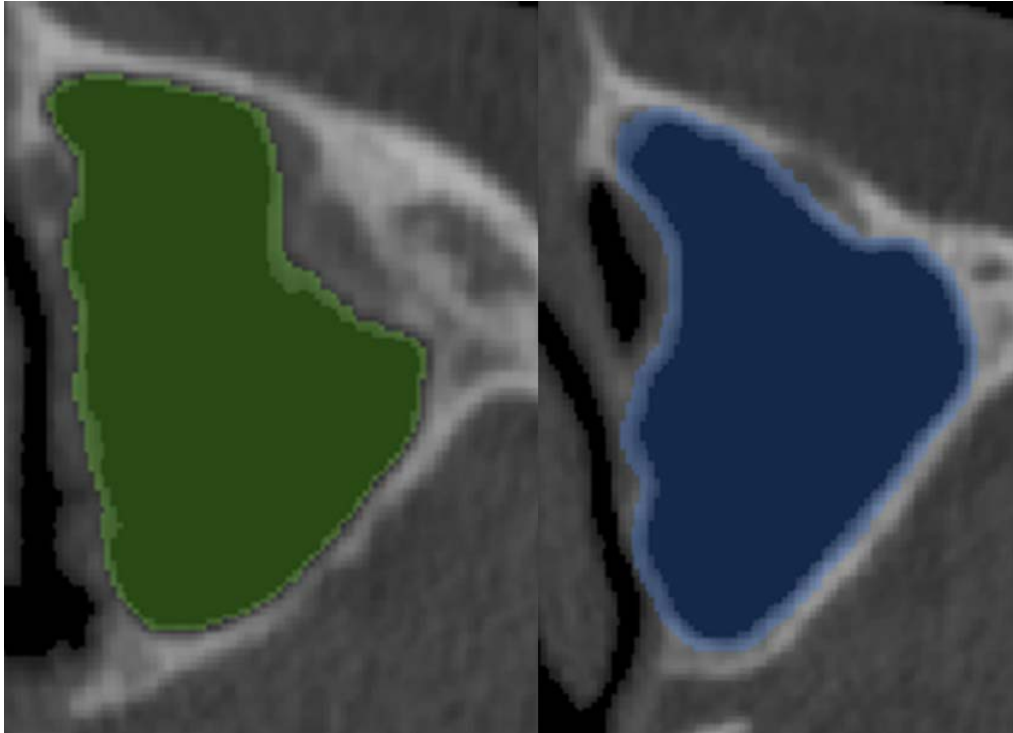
Left is before dilate and right after. These CT slides are not the same.
